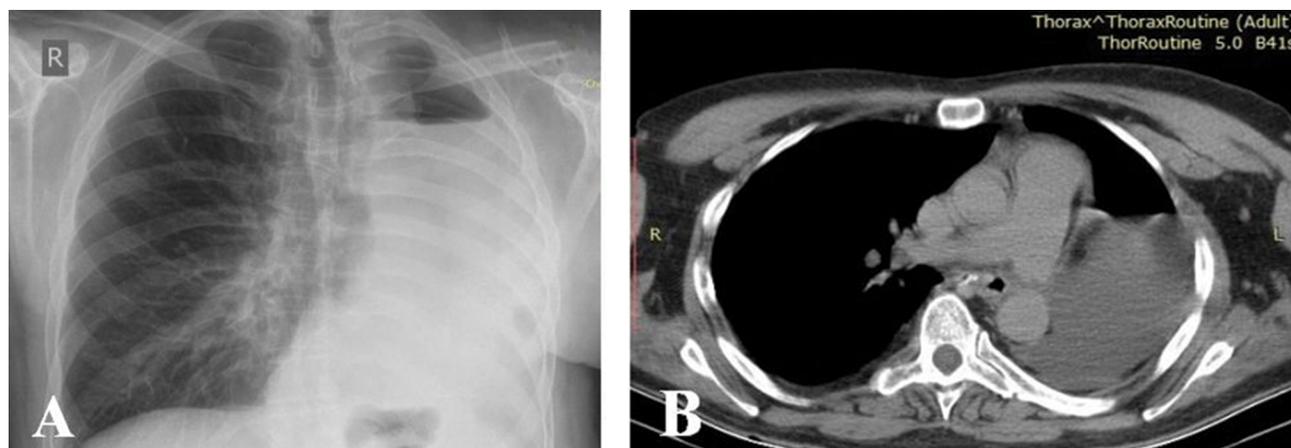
A. Chest X-ray; B. CT one month after left pneumonectomy.
